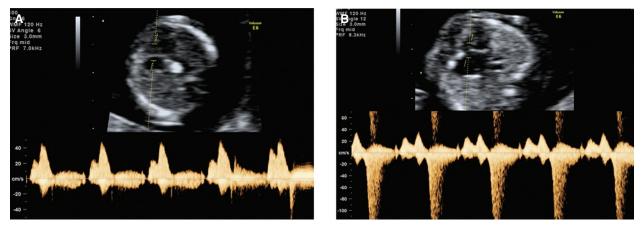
Transverse view of the fetal heart demonstrating Doppler assessment of flow across the tricuspid valve of a fetus at 12 weeks with normal waveform (A) and tricuspid regurgitation (B).
